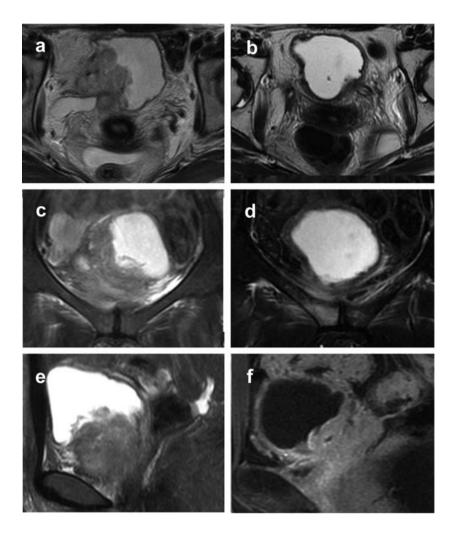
MRI before (a-c) and after (d-f) the treatment. The horizontal (a), coronal (b) and sagittal (c) MRI slices reveal that bulky tumors occupy more than half of the bladder cavity, and that the tumors invade the abdominal wall, indicating stage T4. In contrast, all imaging studies (d, horizontal; e, coronal; and f, sagittal slices) confirm complete disappearance of the tumors, and that the mucosa and muscle layer are intact, at 10 weeks after completion of the therapy.
